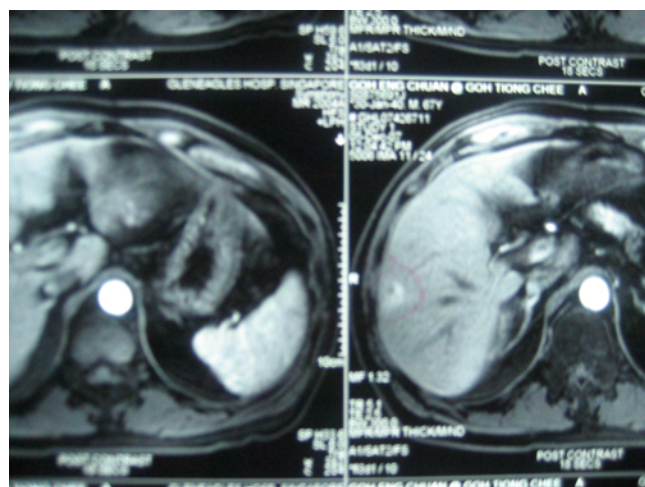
MRI showing enhancement – T 2 weighted image
